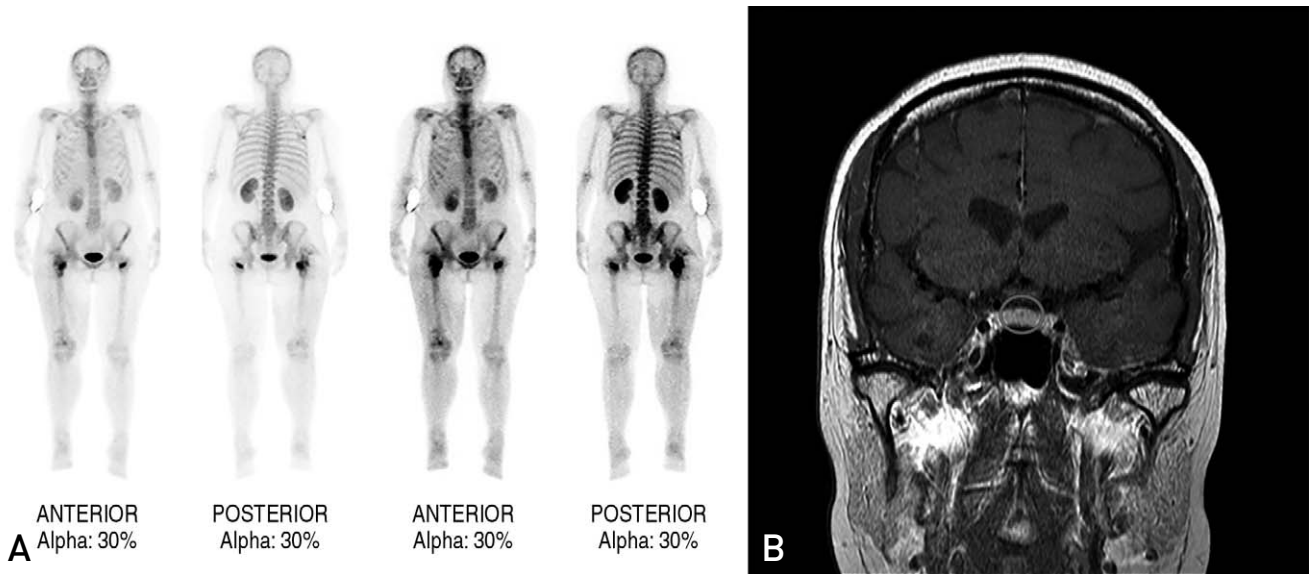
(A) Triple-phase bone scan using 25 mci of 99 mTc-DPD showed increased vascularity and bony uptake only in the region of both the right and left femur. (B) The sella magnetic resonance imaging showed no evidence of definite focal lesion in the pituitary gland (circle).
